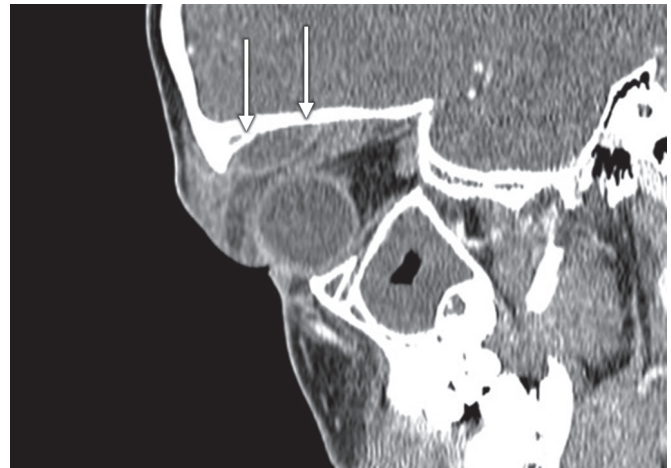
Sagittal CT scan after cessation of steroids demonstrating persistent subperiosteal abscess (arrows) in the superior aspect of the orbit.
